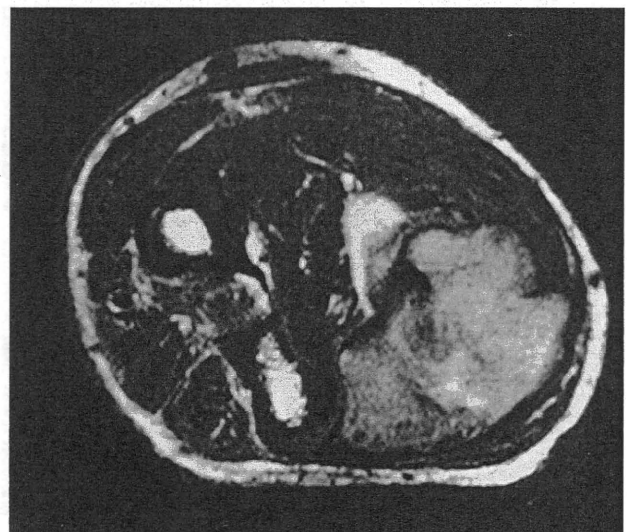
MRI findings in Case 1 with MFH arising in the forearm. Axial T1-weighted imaging.
